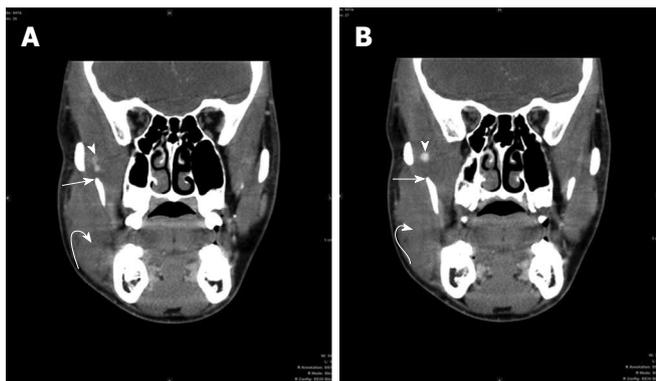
Three millimeter reconstructed contrast enhanced coronal computed tomography images of the face with soft tissue settings demonstrate swelling of the entire right temporalis muscle more prominent at its myotendinous insertion to the mandible (straight arrow). There is also swelling of right masseter muscle (curved arrow). Small high density material is again seen in region of myotendinous insertion of right temporalis muscle suggesting hemorrhage (arrowhead).
